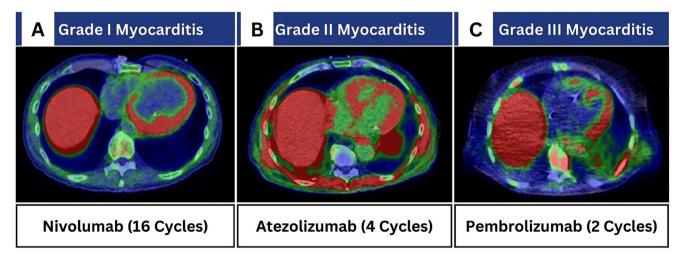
(A-C) Fused Gallium-68 (⁶⁸Ga)-1,4,7,10-tetraazacyclododecane-1, 4,7,10-tetraacetic acid Tyr3-octreotide (⁶⁸Ga-DOTATOC) positron emission tomography/computed tomography (PET/CT) images were performed for three cancer patients treated with immune checkpoint inhibitors. The fused axial cardiac PET/CT views reveal (A) diffuse ventricular wall ⁶⁸Ga-DOTATOC expression, or (B, C) patchy ventricular wall ⁶⁸Ga-DOTATOC expression correlating with clinically confirmed immunotherapy-induced myocarditis. All figure subpanels were reproduced from Figure 1 of previous original research by Boughdad under the Creative Commons license (CC BY 4.0) (19)
